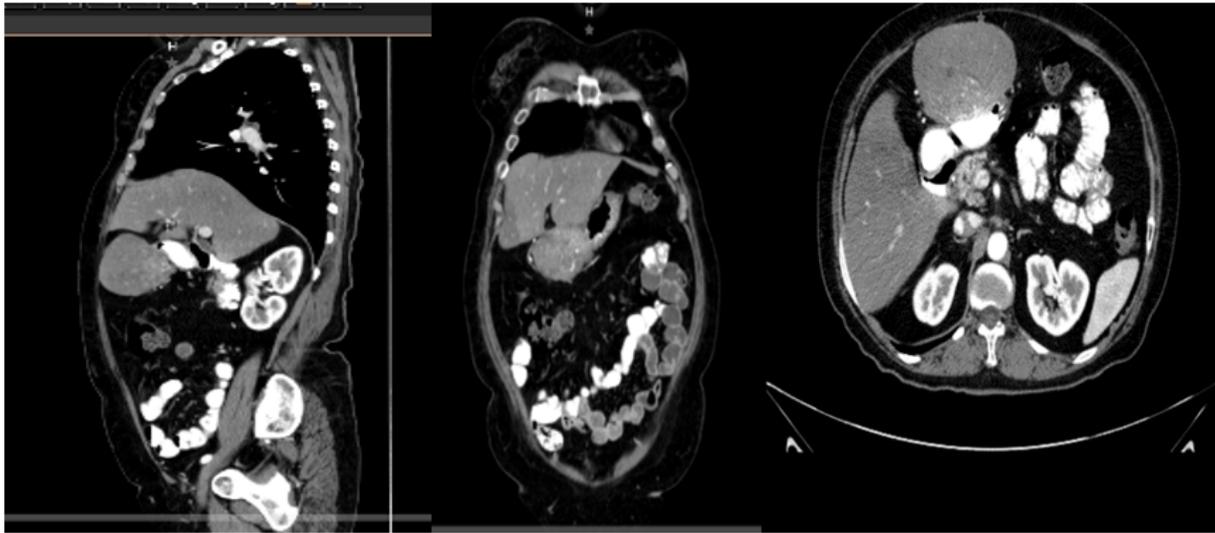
GIST tumor by CT, sagittal, coronal and axial section. The tumor is subhepatic and comes from the gastric antrum. Image obtained from the HIS system, Hospital de Especialidades del CMN la Raza.
